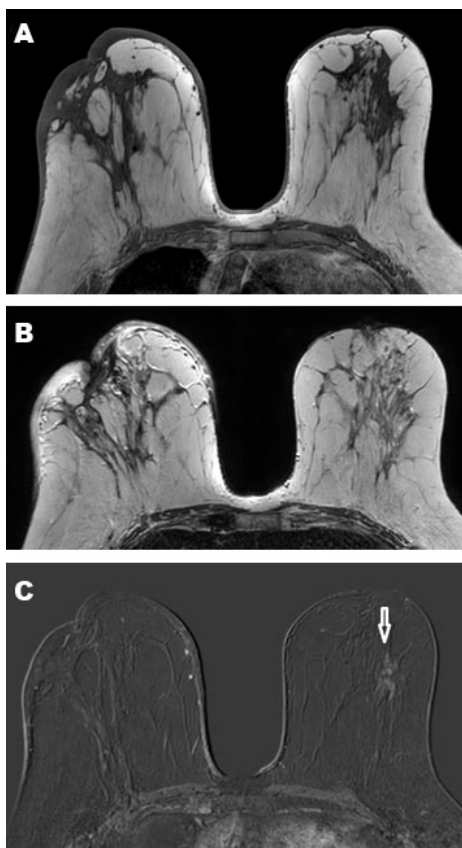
Breast MRI in (A) T1, (B) T2-weighted sequences with subtracted image (C) showing a nodular non-mass enhancement with linear distribution, in the junction of the external quadrants of the left breast measuring 3 cm.
